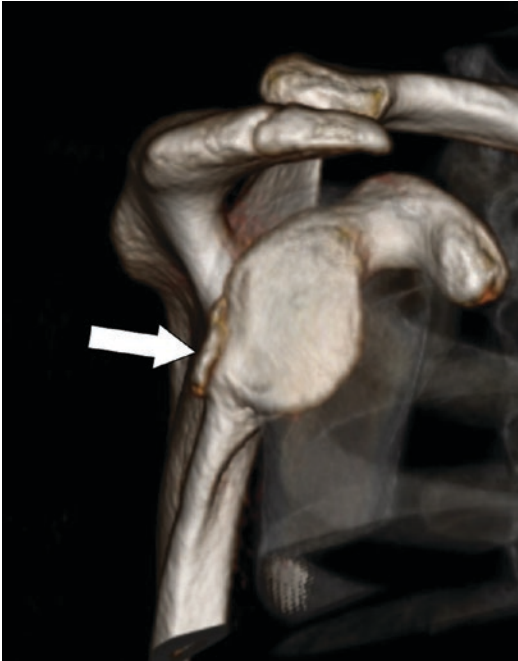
Reverse osseous Bankart lesion. A disarticulated 3D CT image of the scapula shows a fracture of the posterior glenoid rim with a displaced fragment (arrow) in a patient who had sustained a posterior glenohumeral joint dislocation
